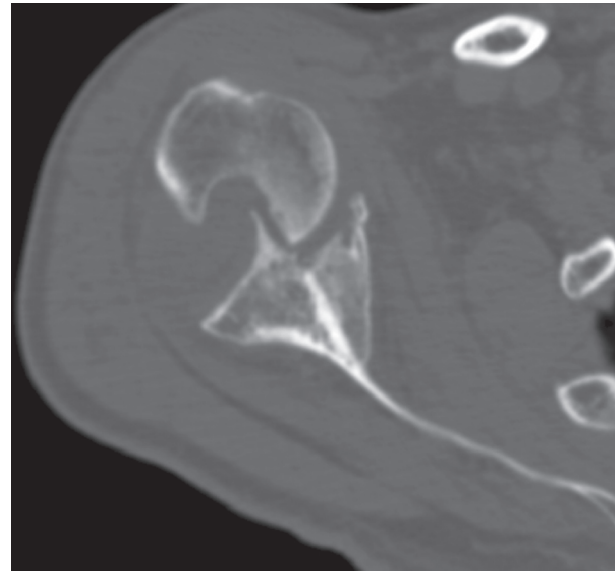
Axial CT image of chronic dislocation and peri-articular ossification.
